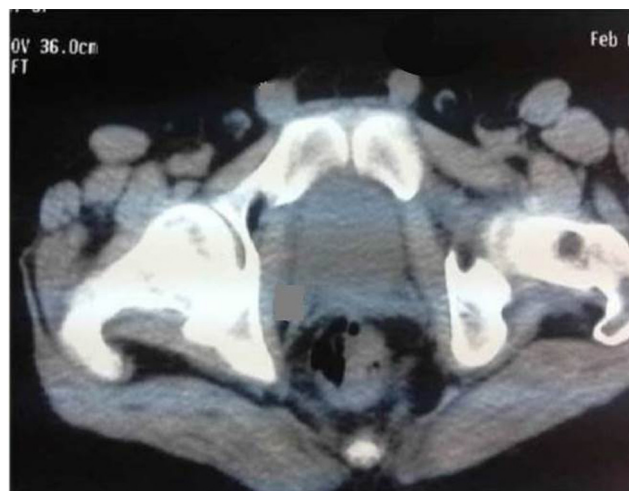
Pelvic CT: axial section through the uterine region and through the two inguinal structures.
